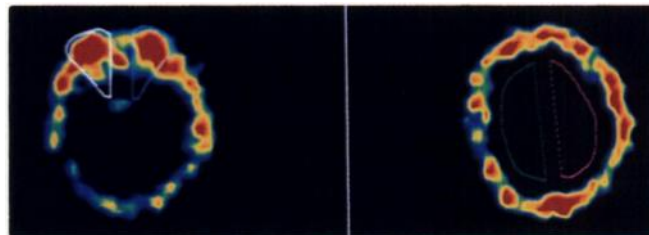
Semiquantitative evaluation was performed using SPECT slices with irregular ROIs placed over the orbits and as references over both hemispheres.
